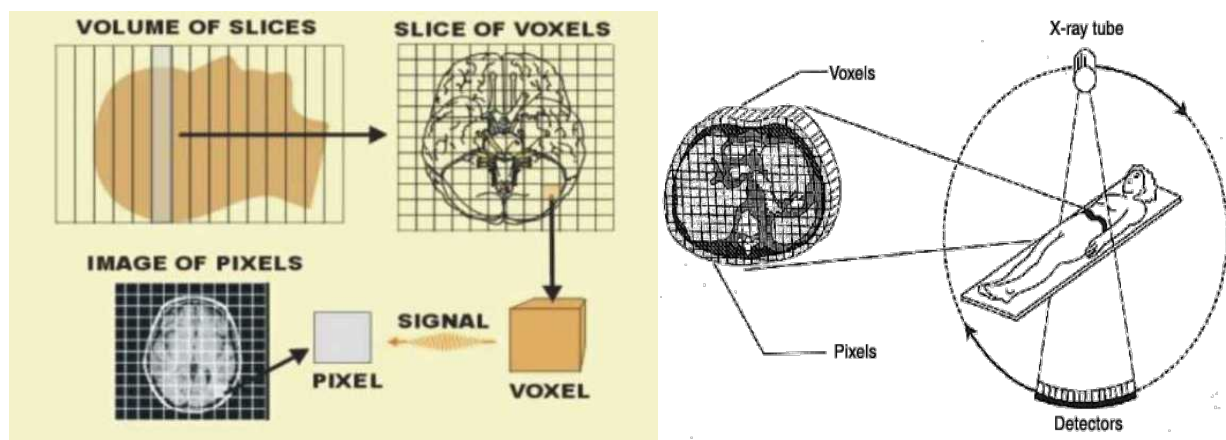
9: Stages of the formation of the computed tomography image^{15,16}
